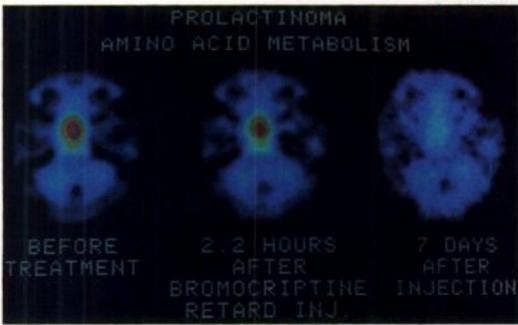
Patient with prolactinoma examined with ^{11}C -methionine before and after initiation of bromocriptine treatment. The initially very high metabolism in the tumor is already, within a few hours after start of treatment, markedly reduced. One week after start of treatment the amino acid metabolism is reduced by 80%. Still in this instance no effect on tumor size can be seen with CT or MRI, but 3–6 mo later a tumor size reduction was observed.
